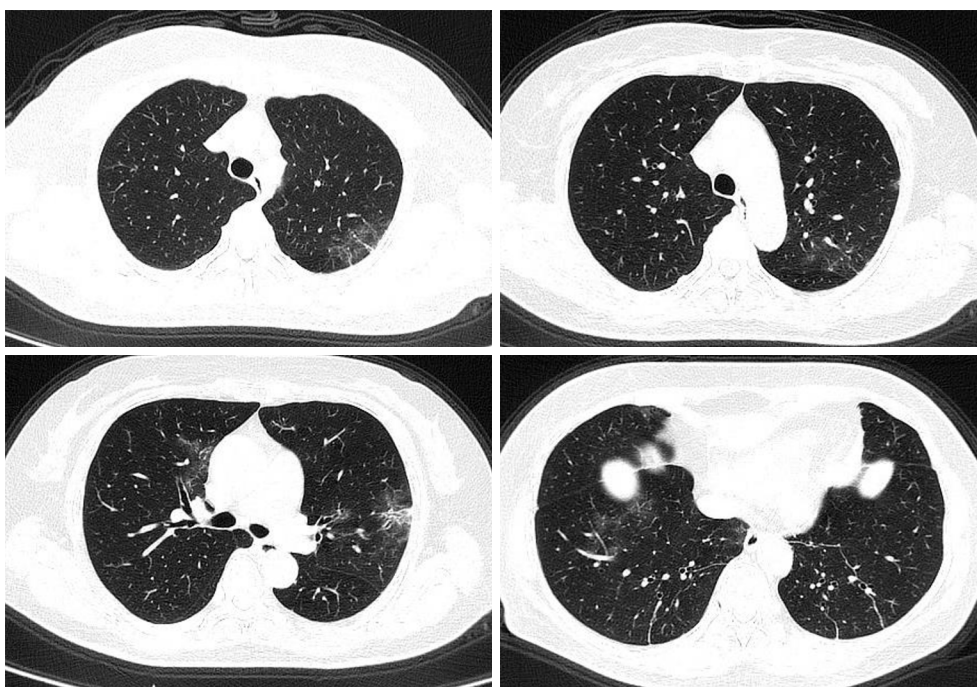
Case 4, a 69 years old female, chest CT shows that bilateral lungs mottled ground-glass opacity with unclear boundary and multiple linear shadows.
